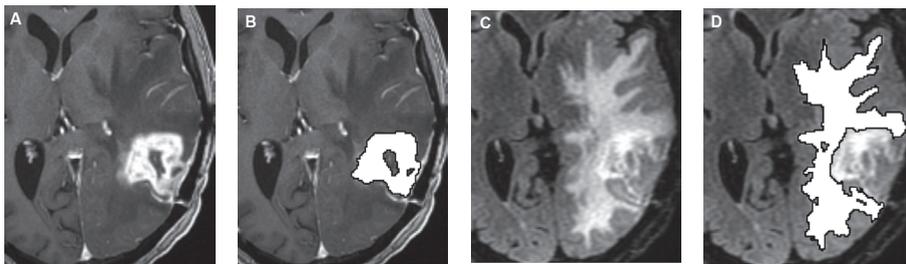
(A-D): 3D T1-weighted post-contrast and 3D T2w/FLAIR images without (A, C) and with (B, D) volumes of interest (VOI) in the same patient. The enhancing VOI was subtracted from the non-enhancing VOI to obtain the truly non-enhancing portion of the tumor.
